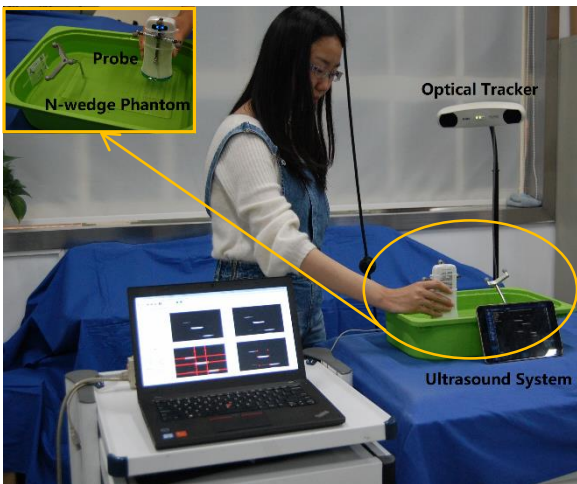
Hardware configurations of the ultrasound calibration system
